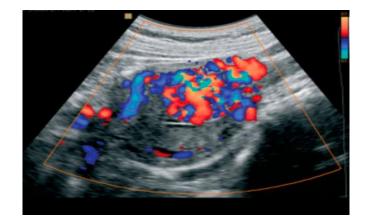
Doppler Ultrasonography showing Hypervascular Lesion
